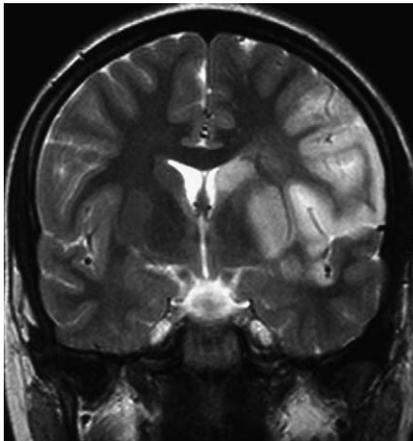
Brain MRI revealing a stroke in the territory of the middle cerebral artery in a 12-year-old girl with SLE and antiphospholipid syndrome.
